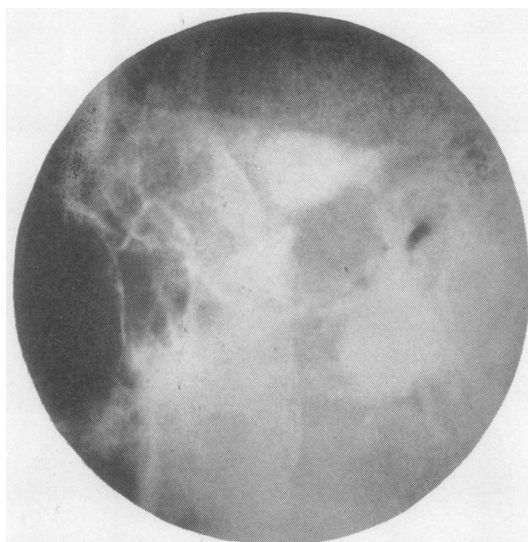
Right temporomandibular joint in open position. Standard radiograph showing results of progressive destruction of condyle head, leading to an appearance similar to "the mouth-piece of a flute."
